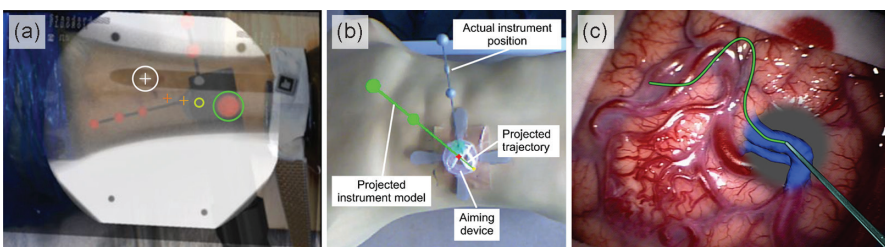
(a) AR view for interlocking of intramedullary nails: overlay of live video, x-ray, and alignment targets. (From Diotte, B. et al., *IEEE Trans. Med. Imaging*, 34, 487–495, 2015.) (b) AR view for percutaneous needle insertion showing real instrument and alignment target. (From Seitel, A. et al., *Int. J. Comput. Assist. Radiol. Surg.*, 11, 107–117, 2016.) (c) Tracing of virtual blood vessels using the surgical pointer. Trace is then used for registration correction. (From Drouin, S. et al., Interaction-based registration correction for improved augmented reality overlay in neurosurgery, in *Augmented Environments for Computer-Assisted Interventions*, Lecture Notes in Computer Science, Vol. 9365, pp. 21–29, 2015.)
